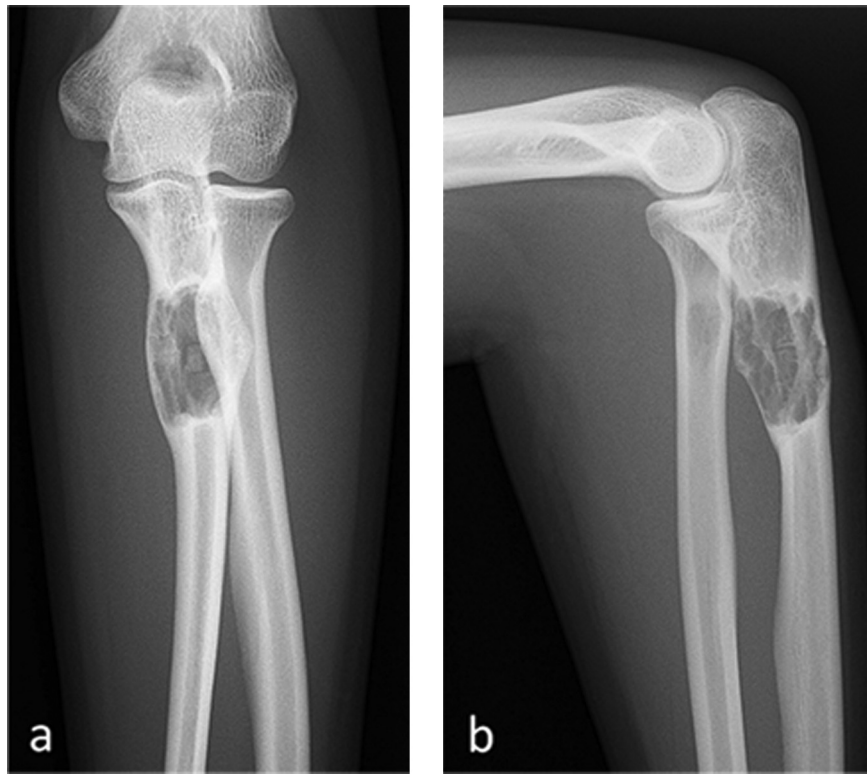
Anteroposterior (a) and lateral (b) plain radiographs, showing a well-defined, lytic, and expansile lesion, with marginal thin sclerosis and trabeculation in the proximal ulna.
